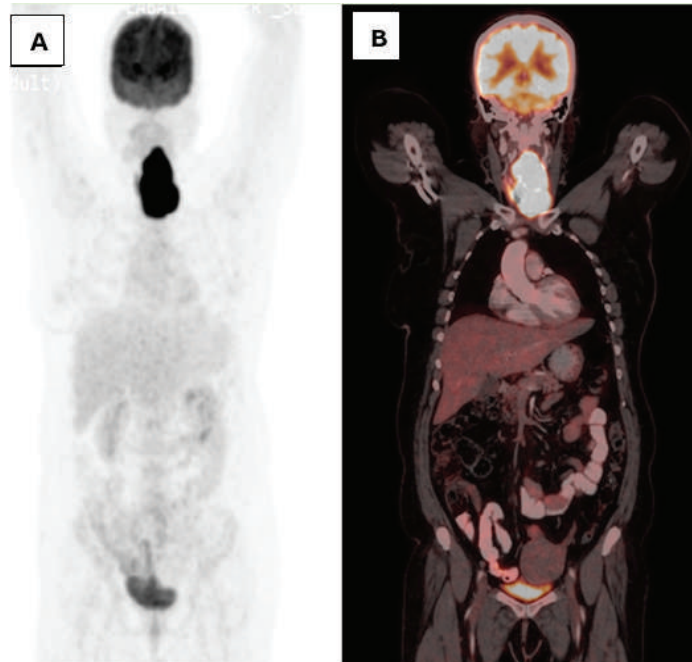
Baseline Maximum Intensity Projection (MIP) image (A) and fused ¹⁸F-FDG PET-CT coronal view (B) showed a large lobulated hypermetabolic soft tissue mass involving the left lobe of the thyroid gland
